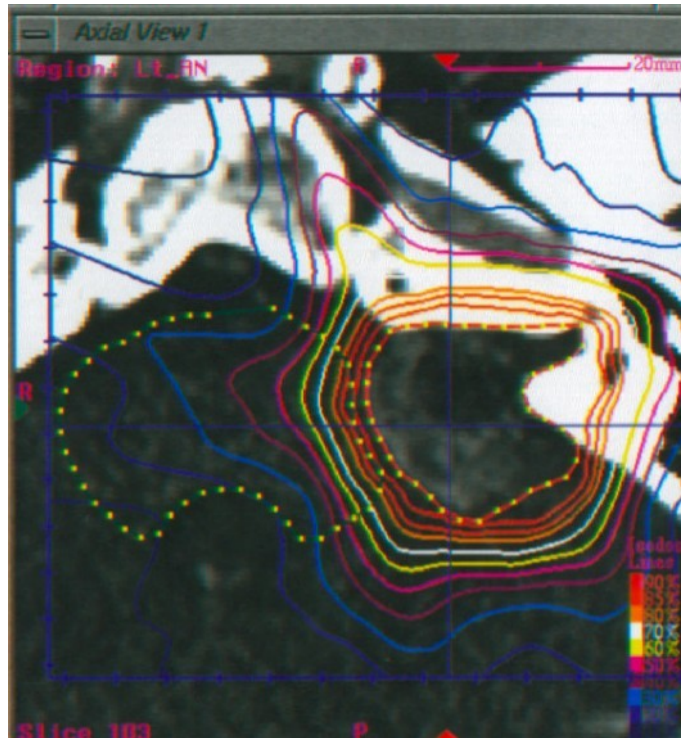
Axial MRI demonstrating CyberKnife/stereotactic radiosurgery treatment planning for a right-sided vestibular schwannoma. Isodose lines show the conformal radiation dose distribution targeted to the tumour with sharp dose falloff protecting the brainstem and cochlea.
